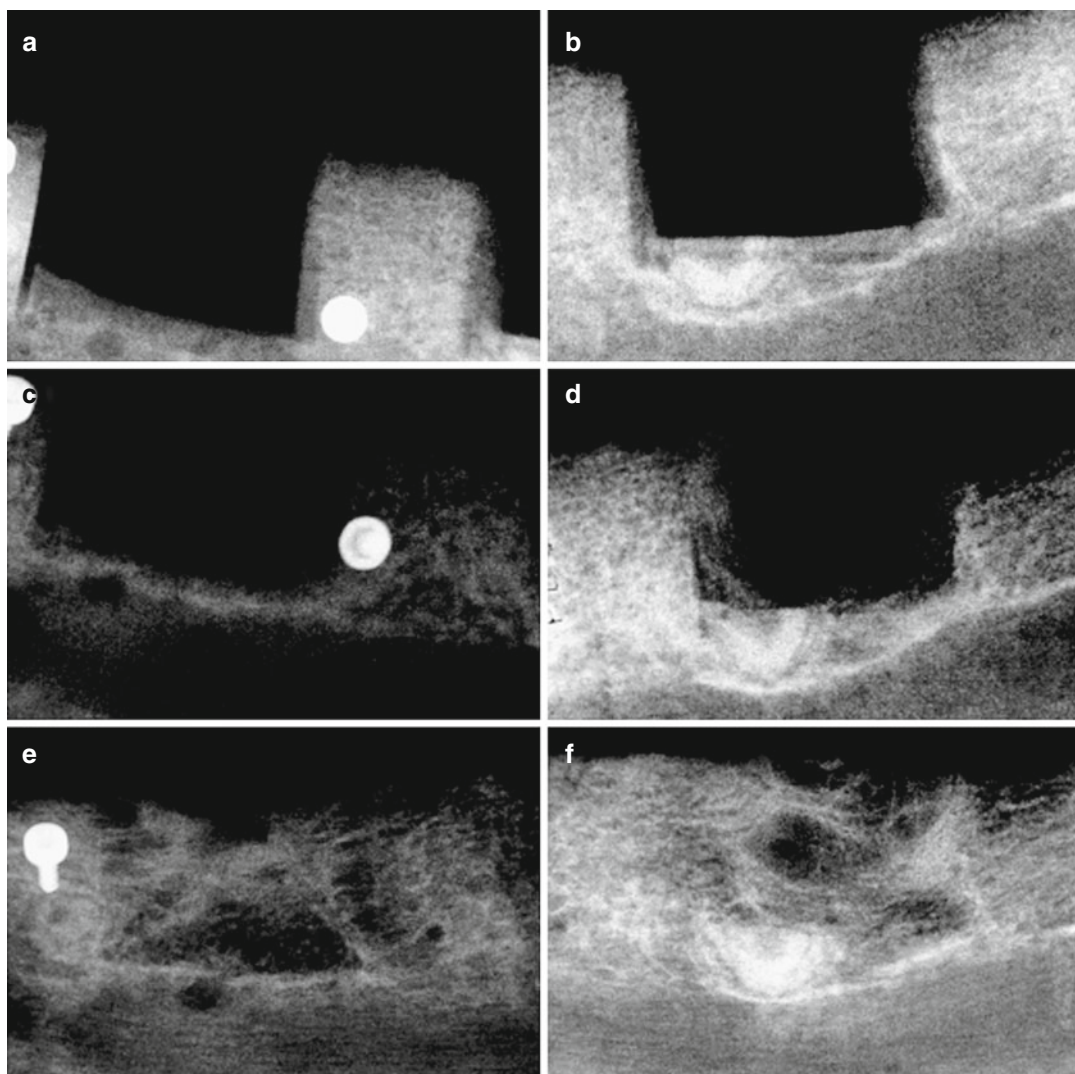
Representative radiographs from immediately post surgery, weeks 4 and 12 post-surgery for sites receiving guided bone regeneration (GBR) (a, c, e) or recombinant human bone morphogenetic protein-2 (rhBMP-2)/absorbable collagen sponge (ACS) (b, d, f). Note bone formation from the mesial, distal, and apical
